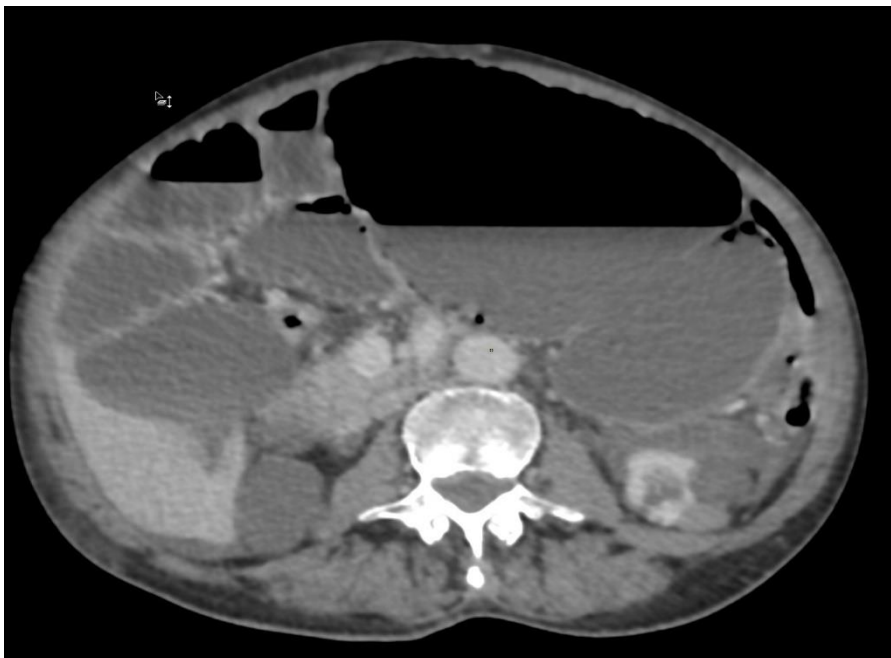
CT image showing a distended caecum tilted at the level of the left hypochondrium
